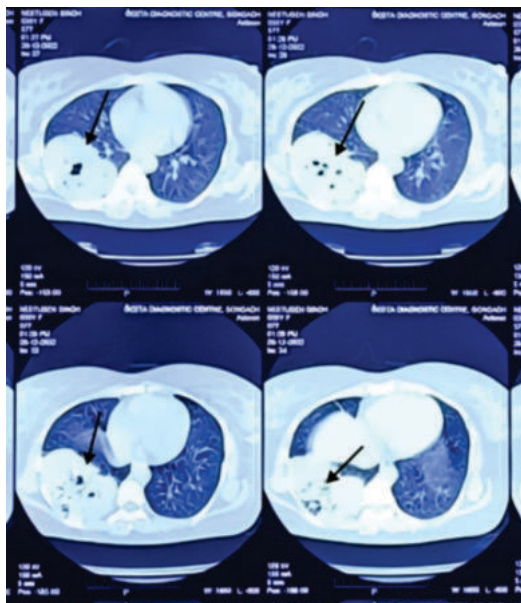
CT Scan At The Level Of Lungs Showing Large
